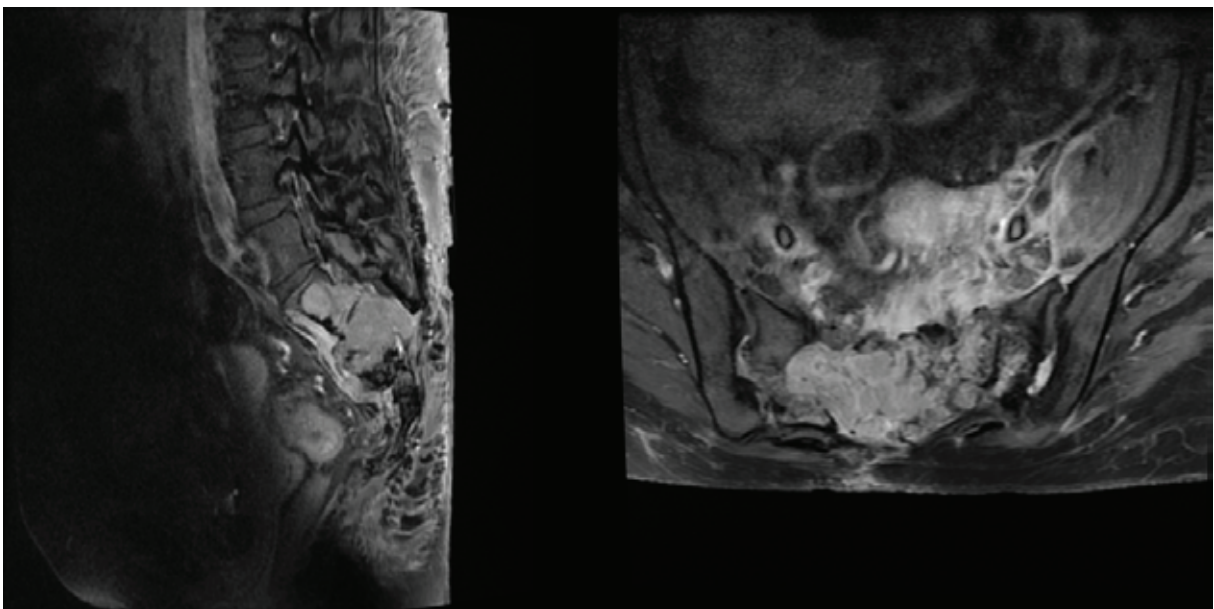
(A, B) Enhanced sagittal T1-weighted MR image shows marked and heterogeneous enhancement of the GCT.
